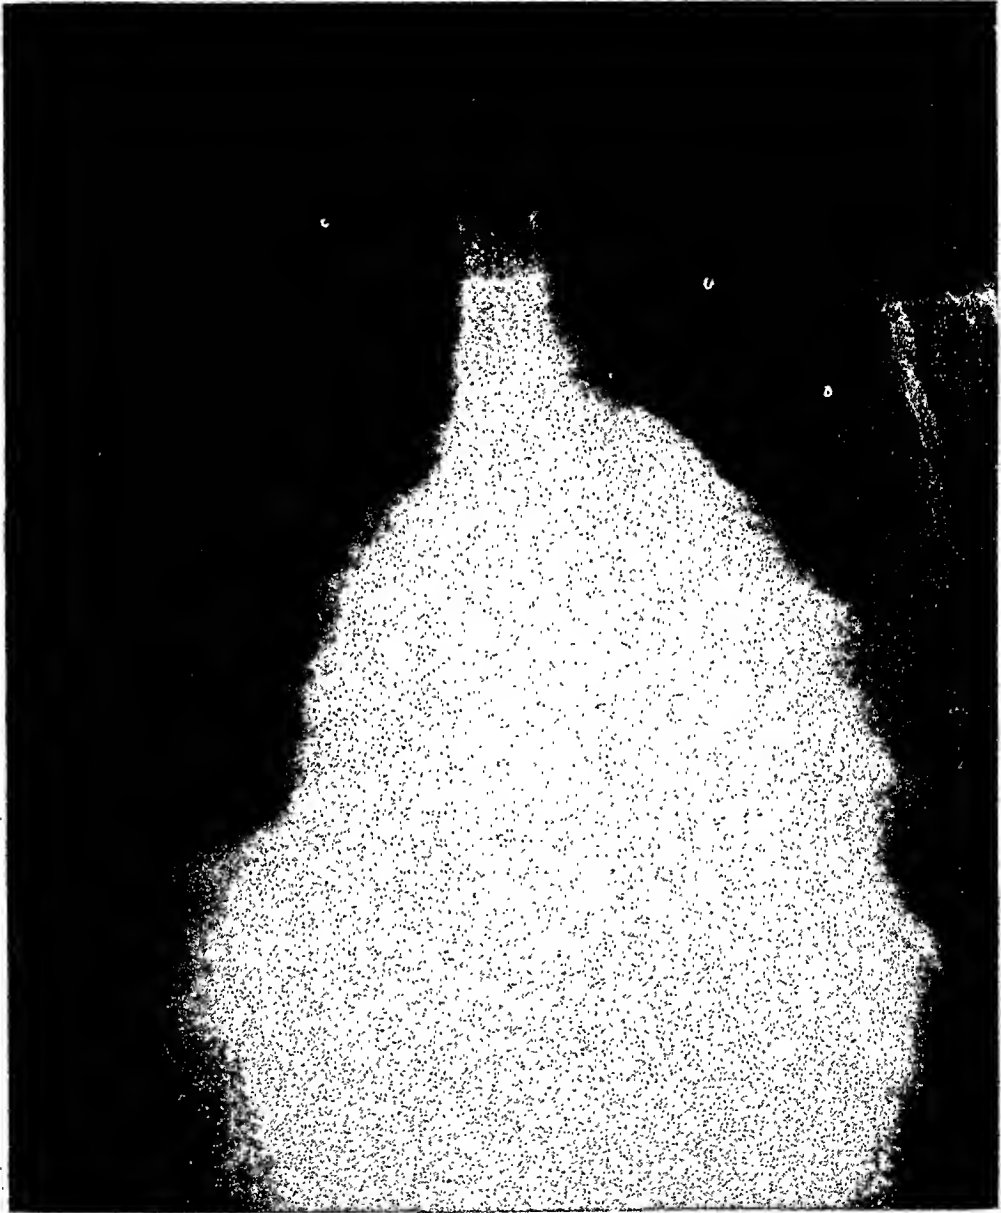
Ordinary x-ray film of patient with mitral and tricuspid stenosis.
